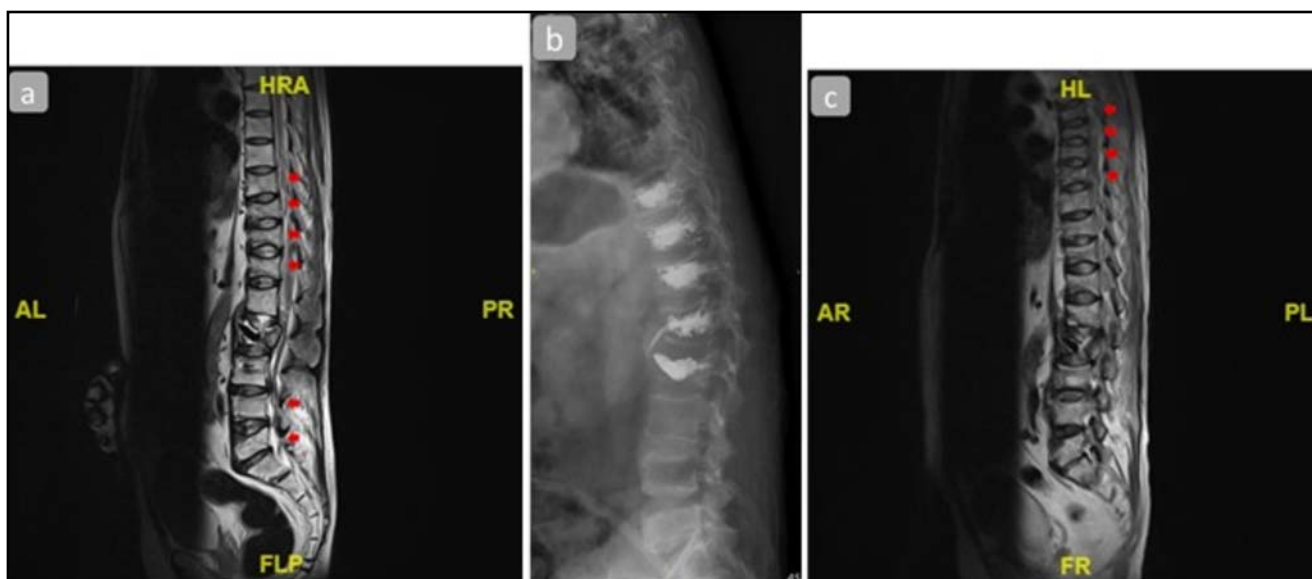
Whole spine T2-weighted (T2W) image sagittal view showed partial compression fractures of the T9-T12, L4 and L5 (a: red arrow). T10-L1 kyphoplasty was performed and the screw implant from the earlier surgery was removed (b). One month later, followed whole spine T2W image showed new T5-T8 compression fractures (c: red arrow).
